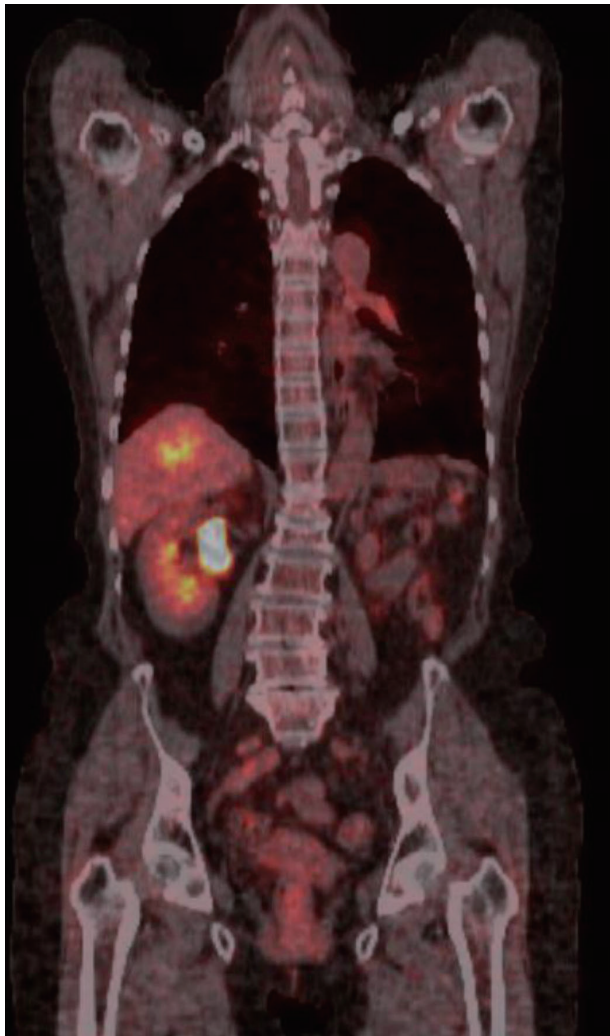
Positron emission tomography-computed tomography findings. Increased FDG uptake in the liver mass is observed.
